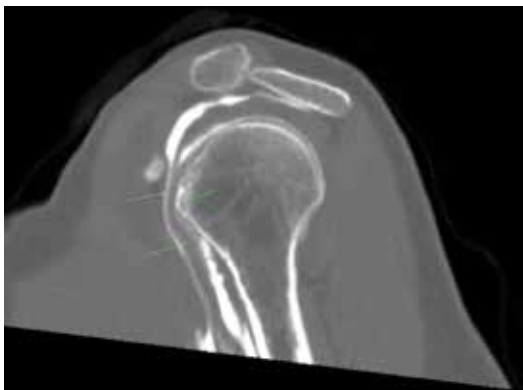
Sagittal view of computed tomography arthrogram showing medial subluxation of the LHBT, related to a SSC tear. The LHBT is in front of the lesser tuberosity.
